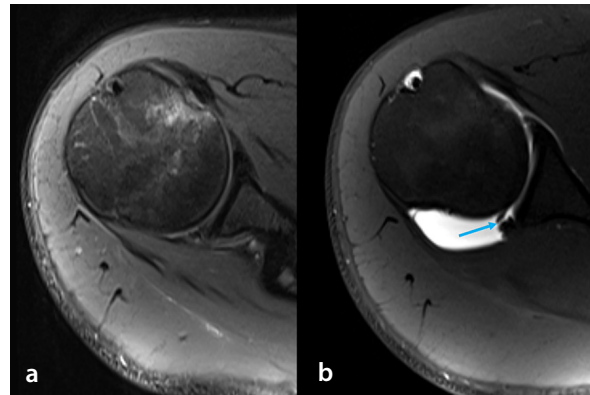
Transverse plane PD MR imaging (a) of the right glenohumeral joint shows no pathological findings in the posterior labrum; however, SE T1-weighted MR arthrography (b) clearly reveals a posterior labral defect (blue arrow). PD, proton density; MR, magnetic resonance; SE, spin-echo.
